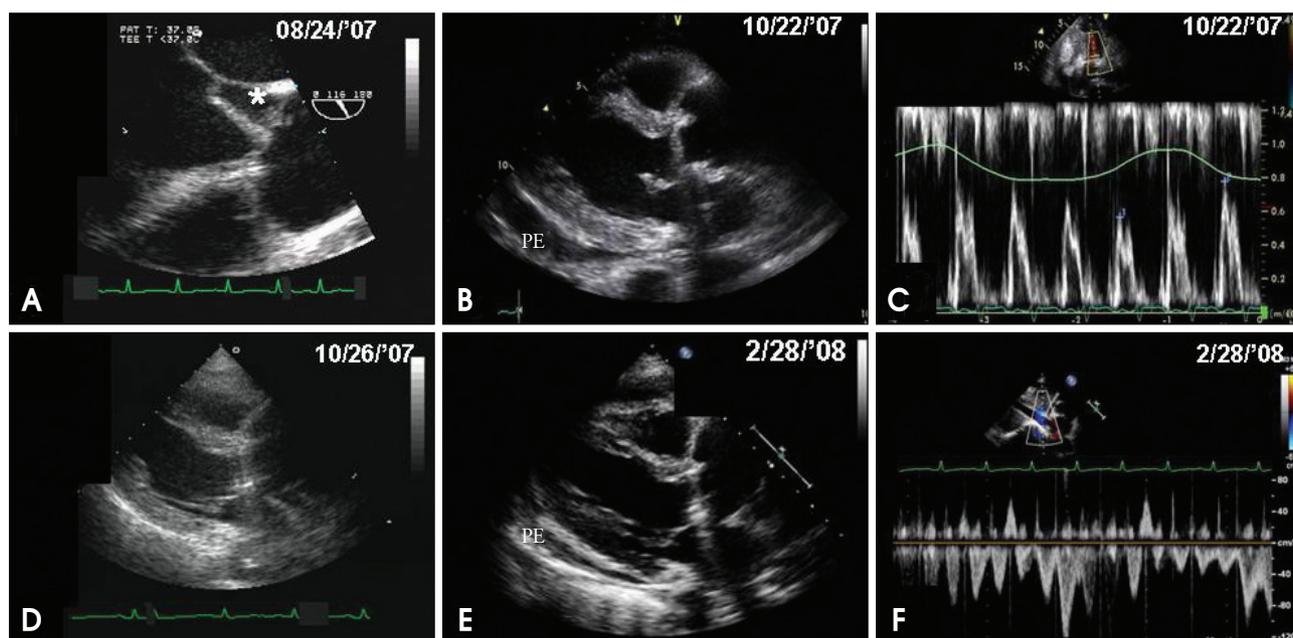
Representative echocardiograms. Preoperative transesophageal echocardiography showed multiple vegetations attached to aortic valve (A). After uneventful aortic valve replacement, moderate pericardial effusion (PE) with typical constrictive physiology developed (B and C), which resolved dramatically with medical treatment (D). After steroid discontinuation, pericardial effusion (E) and constrictive physiology redeveloped (F). Asterisk: vegetations.
